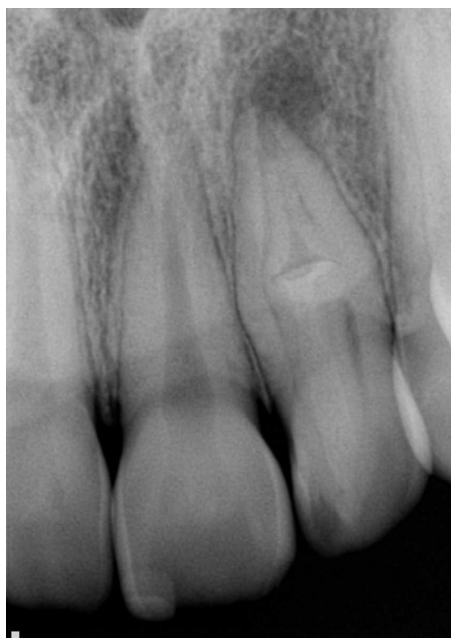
Initial periapical radiograph
